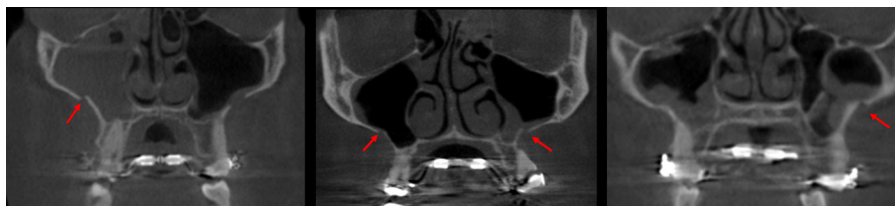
CBCT images showing inward movement of the lateral wall of the maxilla after SARME.
